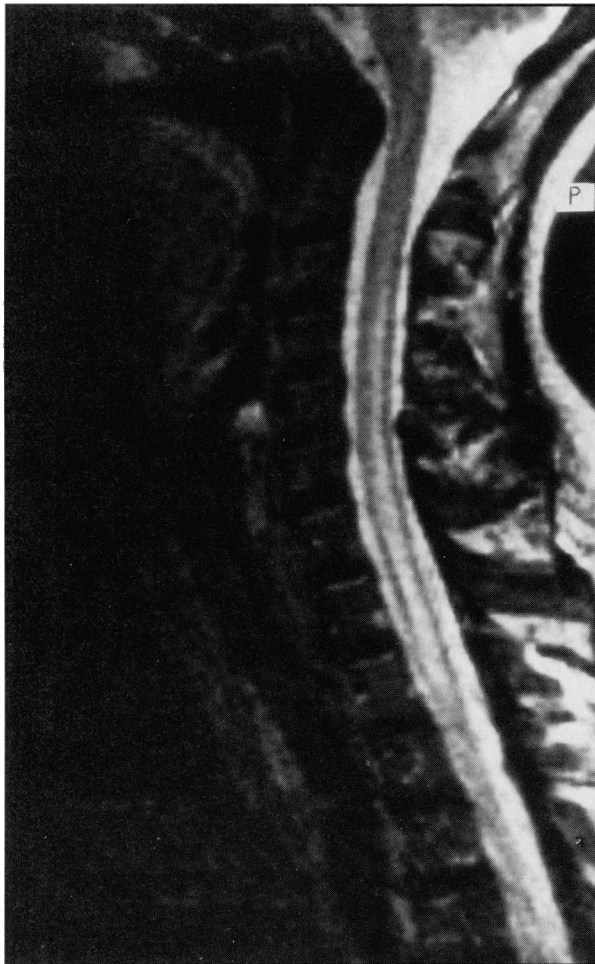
Magnetic resonance image of the spinal cord (C3-T5) showing abnormal signals with edema.
